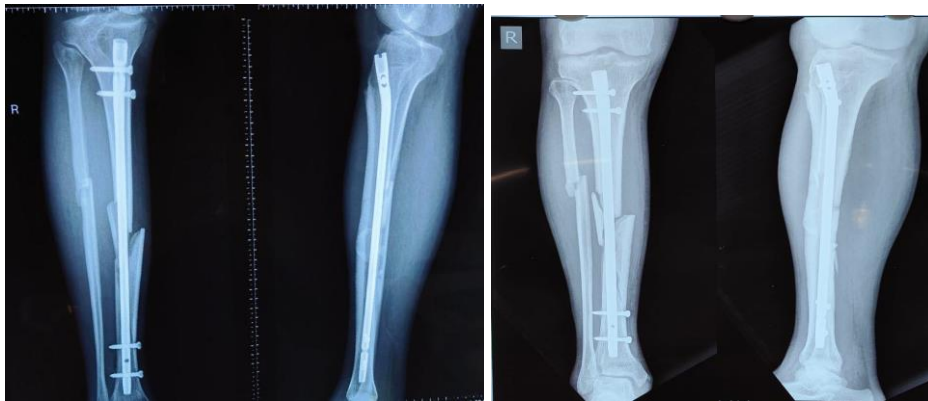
X-ray film of the patient at initial presentation with operation done elsewhere
